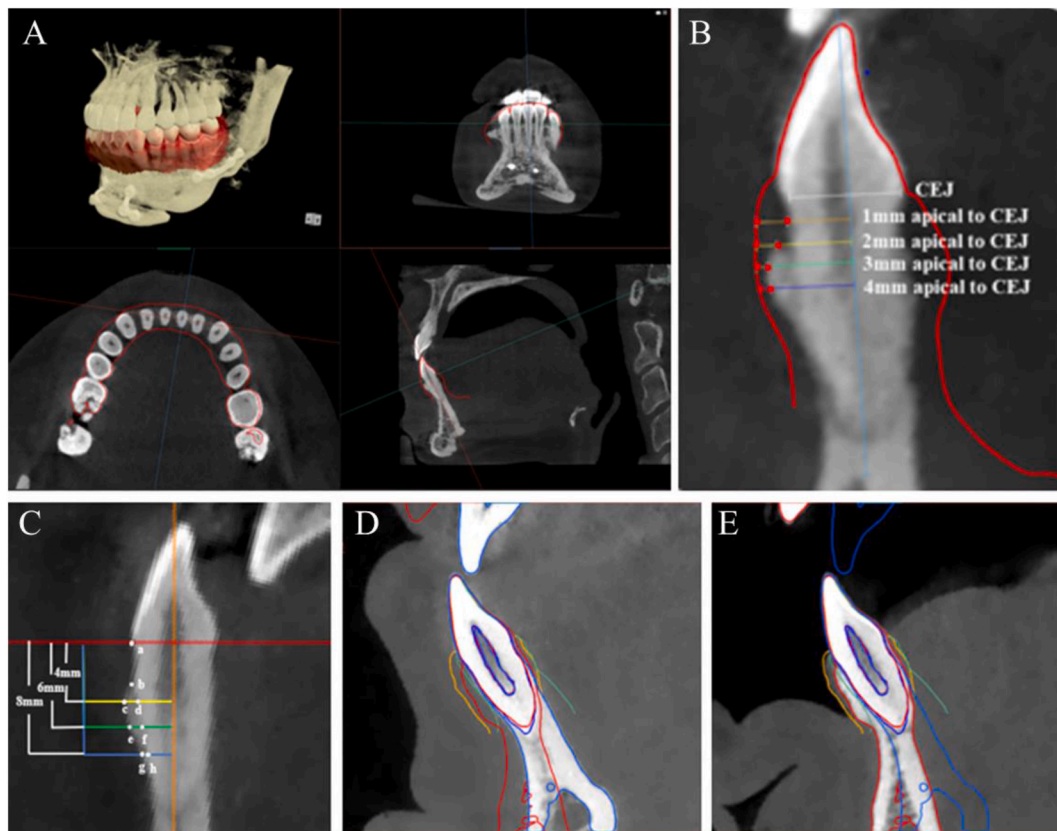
Alveolar thickness and soft tissue measurements A The registration of three-dimensional impression and CBCT images; B The measurement levels of gingival thickness on the combination model; C The measurement levels of bone thickness of the labial aspect, a = labial aspect of the cemento-enamel junction (CEJ), b = labial alveolar crest, c, e, g = limit of the labial cortical surface at 4 mm, 6 mm, 8 mm under CEJ respectively, d, f, h = labial aspect of the root at 4 mm, 6 mm, 8 mm under CEJ respectively. The ab distance was measured as labial alveolar bone height (BH). The cd, ef, and gh distances were measured as the horizontal bone thickness of the labial aspect at 4 mm, 6 mm, and 8 mm apical to CEJ; D E registration of digital impression data and CBCT image of one PAOO patient, blue lines: contour of the pre-orthodontic teeth and alveolar bone; green lines: contour of the pre-orthodontic teeth and gingiva; red lines: contour of the post-orthodontic-orthognathic teeth and alveolar bone; orange lines: contour of the post-orthodontic-orthognathic teeth and the gingiva.
